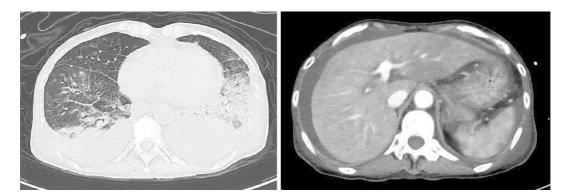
Computed tomography findings. The liver, spleen, and kidneys were found to be enlarged, and inhomogeneous contrast enhancement was seen. Pleural effusion and ascites were present, and consolidation accompanied by air bronchogram was observed in the bilateral lower lobes.
